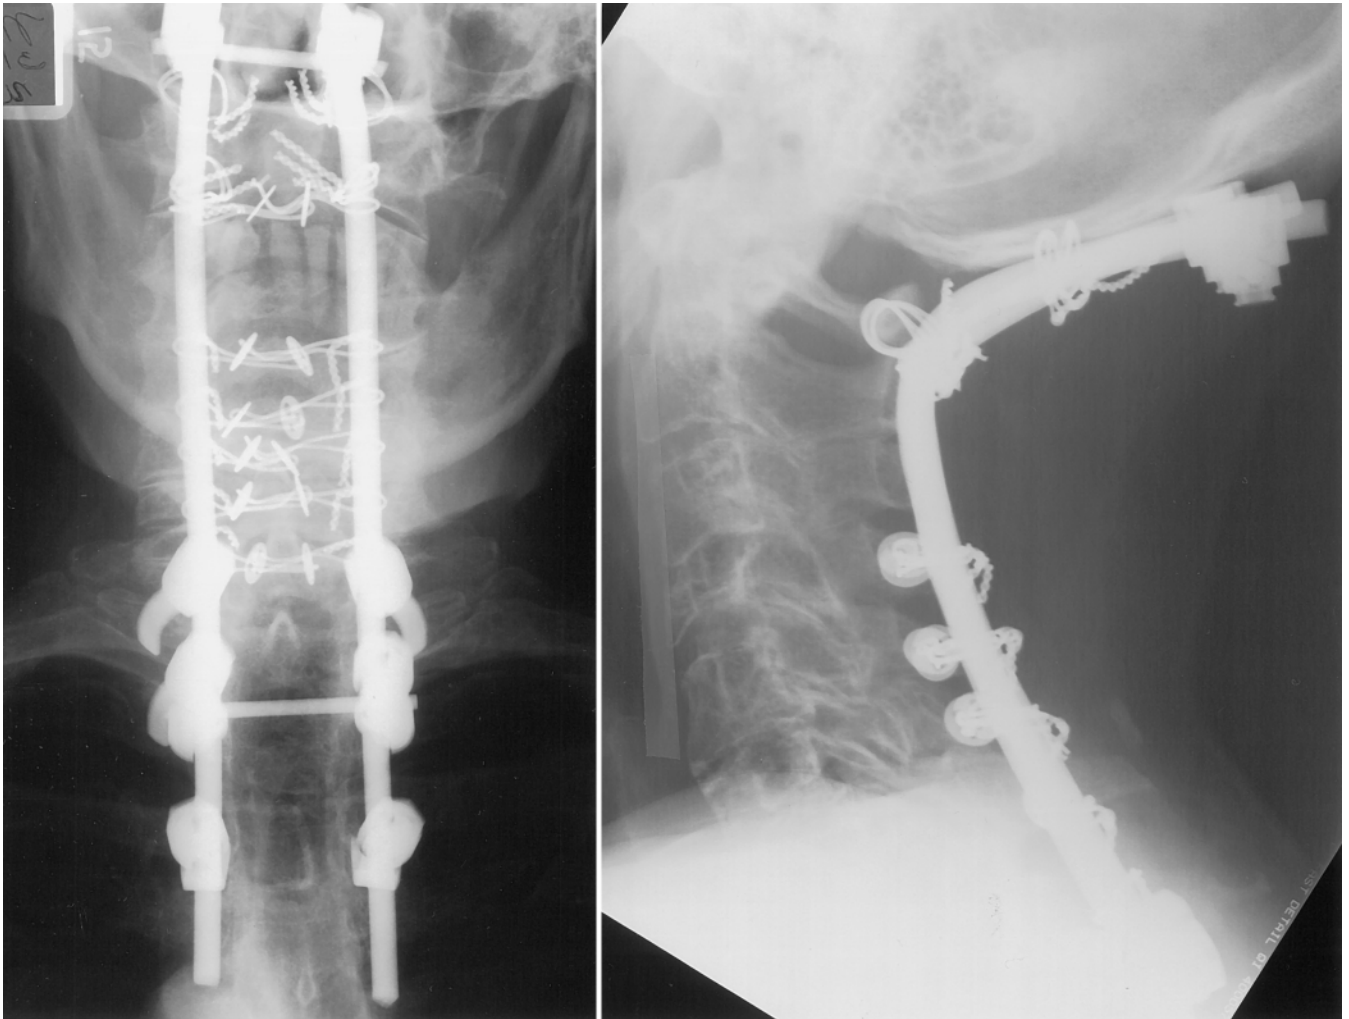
Case 1. Postoperative radiographs obtained 40 months after surgery demonstrating anteroposterior (*left*) and lateral (*right*) views of OCT fixation.
